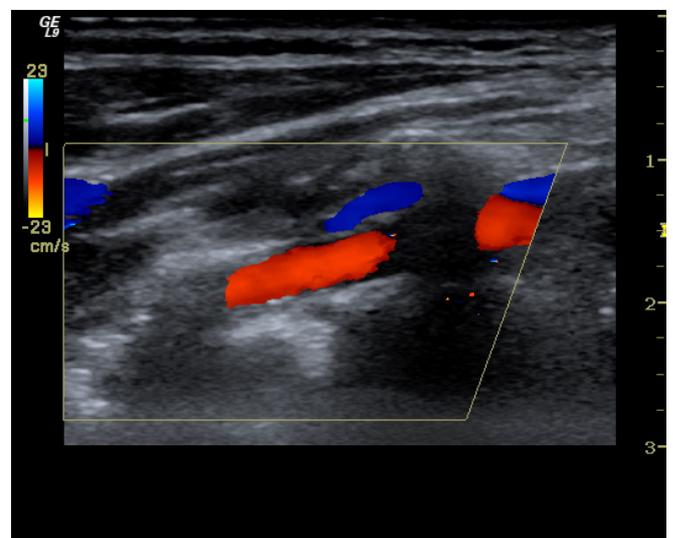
Color Doppler ultrasound imaging of left VA between fifth and sixth cervical vertebrae.
